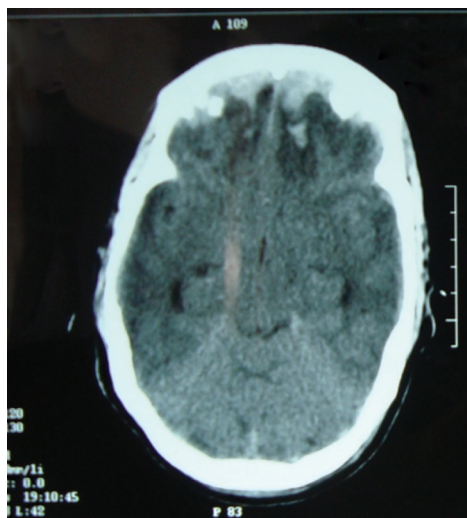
Computed tomography scan on admission showing bifrontal thin subdural hematoma with small contusions and edema.
